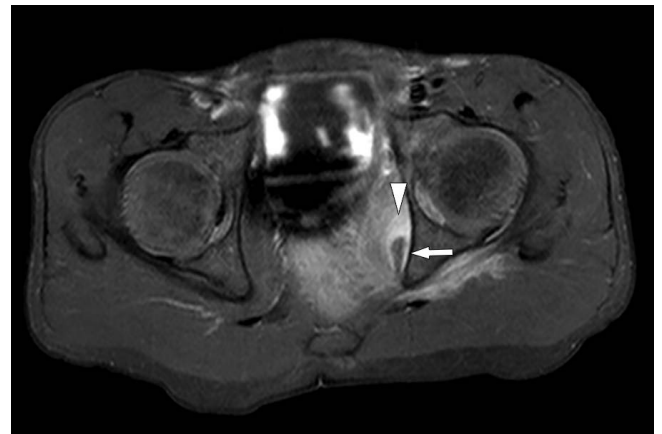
Pyomyositis of the obturator internus muscle. Bilateral hips. MRI. T1 weighted. Contrast enhancement. Axial plane. Level of the femoral heads (same level as Figure 4-2). There is enhancement in the obturator internus muscle (arrowhead). Decreased signal is seen in the area of intense high signal noted on the STIR image in Figure 4-2 (arrow), confirming that this represents fluid (and therefore an abscess in this clinical setting).
